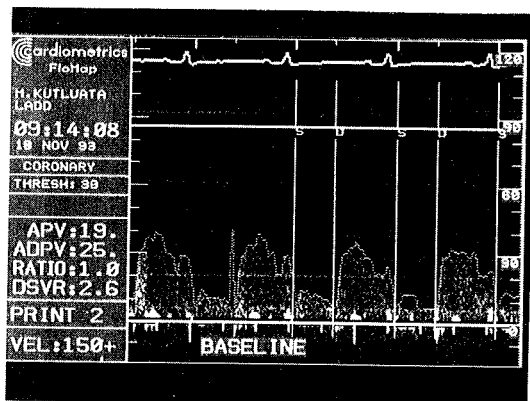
Preoperative doppler echocardiographic evaluation of the patient.
